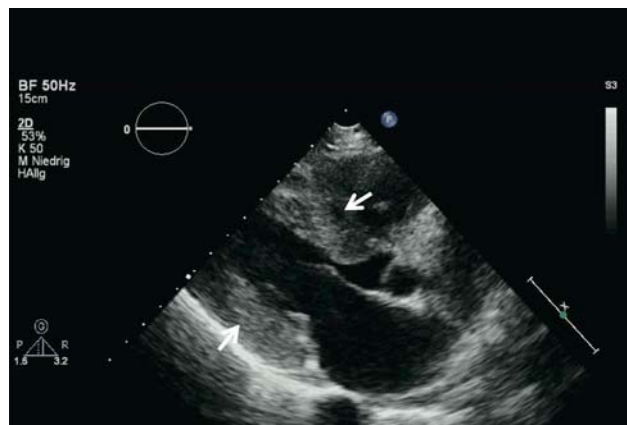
Echocardiography, parasternal longitudinal axis, moderately severe left ventricular myocardial hypertrophy (arrows)
